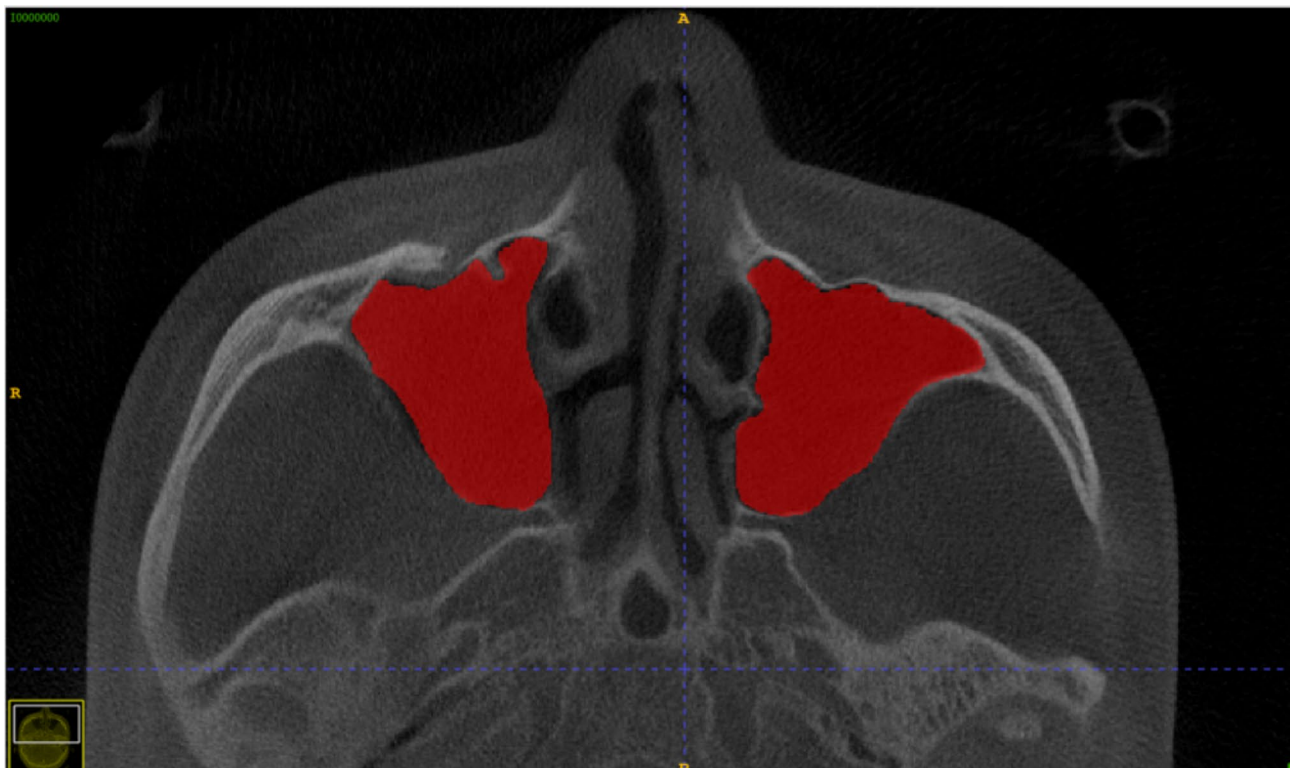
The maxillary sinus labeled in CBCT manually
